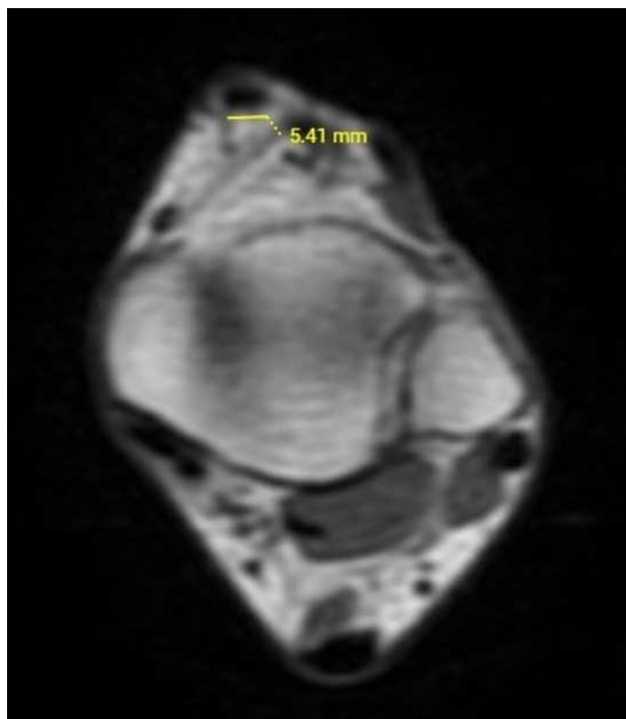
Measurement location of the tibialis anterior main tendon at the level of the medial malleolus on axial T1-weighted images
